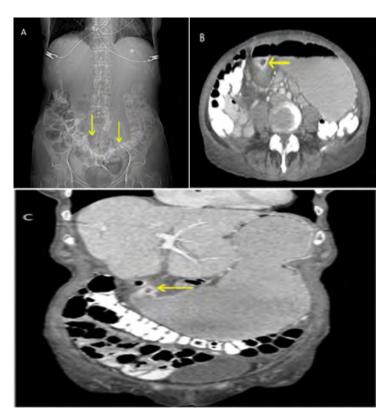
A) Abdominal radiograph showed inferior displacement of transverse colon B) computed tomography (CT) showed a distended stomach, pyloric inflammation C) Computed tomography (CT) showed partial gastric outlet obstruction (GOO).
